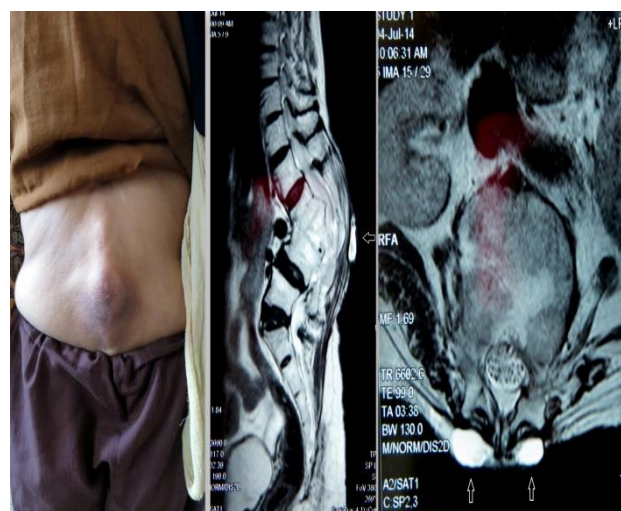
The clinical picture of superficial soft tissue complication over kyphotic deformity (Left), the MRI revealing the hyperintense collection, denoted by arrow, over apex of deformity (middle) and finally the collection in transverse plane indicated by arrows (right).
